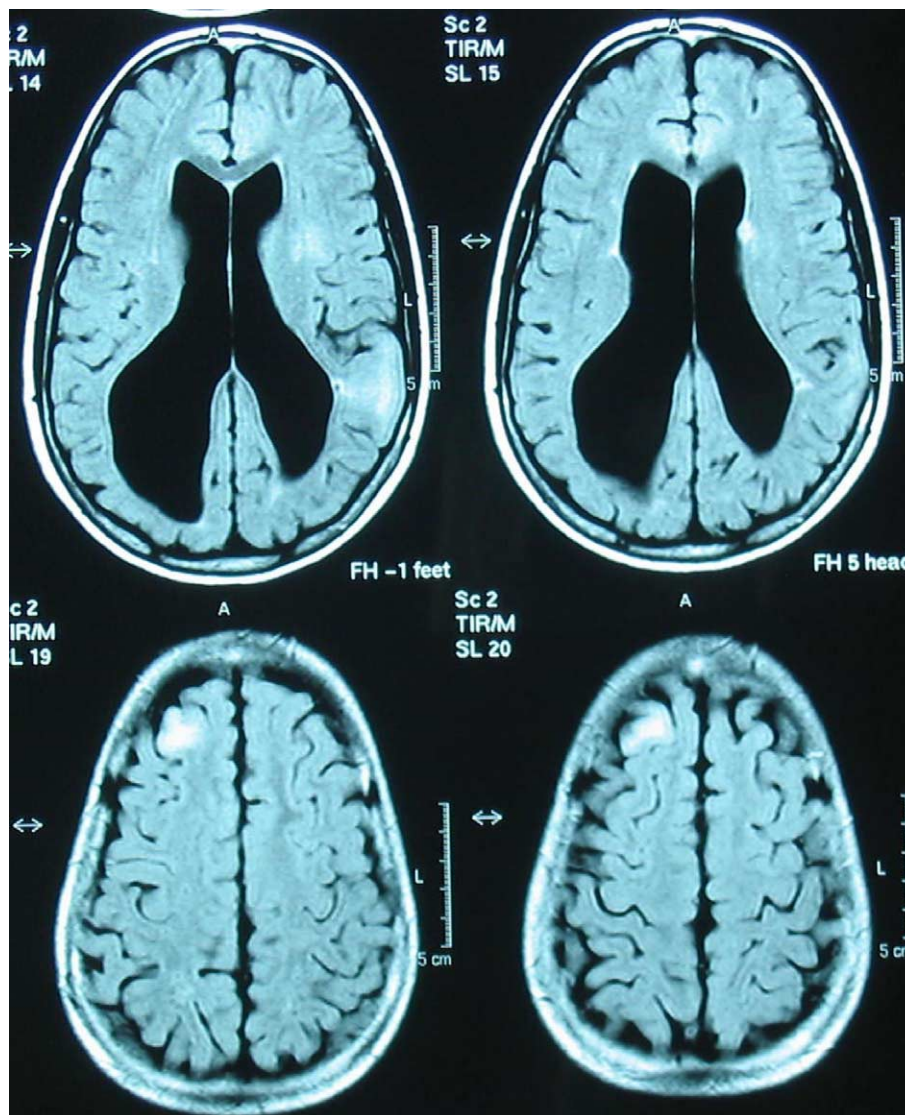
Case 1. FLAIR-weighted axial MRI brain images showing left parietal and right frontal cortical and subcortical tuberos and hyperintense subependymal nodules associated with a marked ex vacuo dilation of both lateral ventriculi with scalloped edges.
